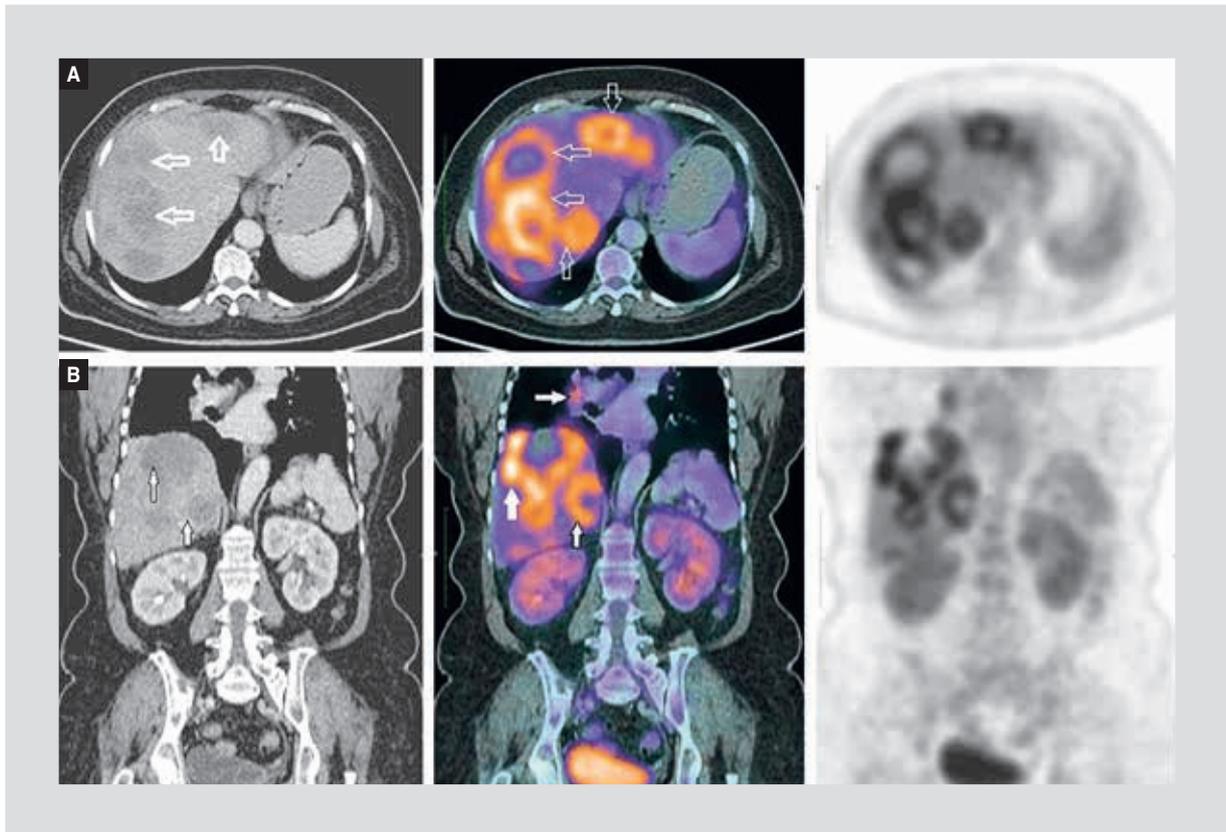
63-year old woman diagnosed with ascending colon invasive, moderately differentiated adenocarcinoma, clinical stage IVA, treated with surgery and chemotherapy. The patient presents CEA elevation to 434 ng/ml. PET/CT scan with ¹⁸FDG was performed and multiple hypodense, hypermetabolic lesions at the liver parenchyma were observed (A), with SUV_{max} of 9.2 (white arrows) and mediastinal lymph nodes (B).
